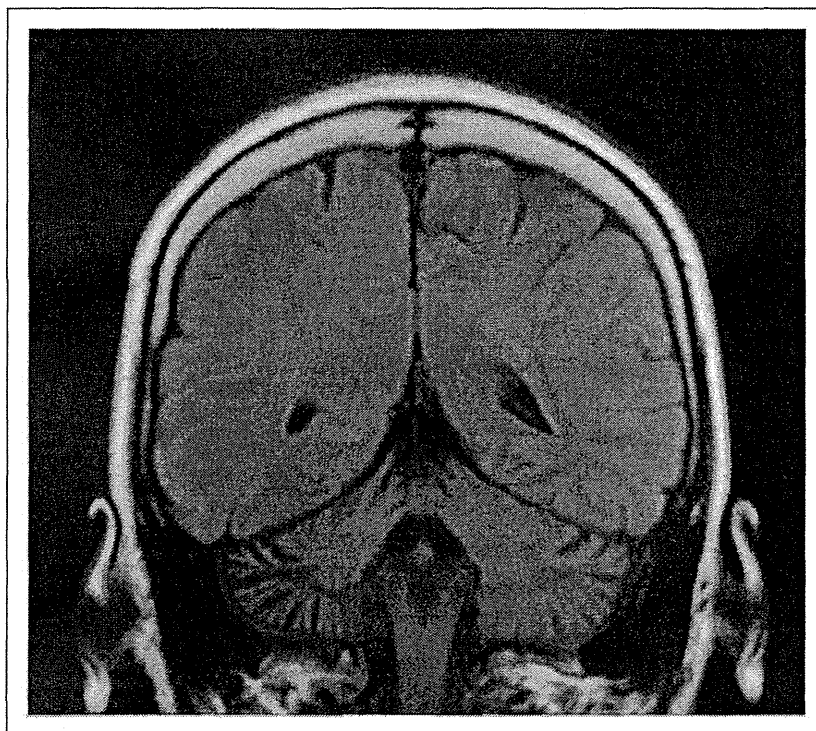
Axial magnetic resonance imaging at follow-up of patient showing no improvement of her atrophic cerebellar hemisphere.
